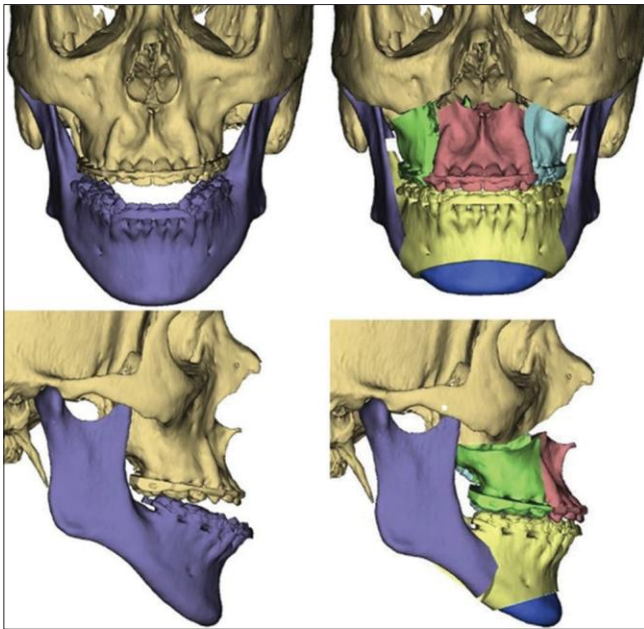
(Left) 3D reconstruction of pre-operative occlusion from cone-beam computed tomography. (Right) 3D rendering of the virtual surgical plan of 3-piece Le Fort, mandibular bilateral sagittal split osteotomy, and genioplasty
